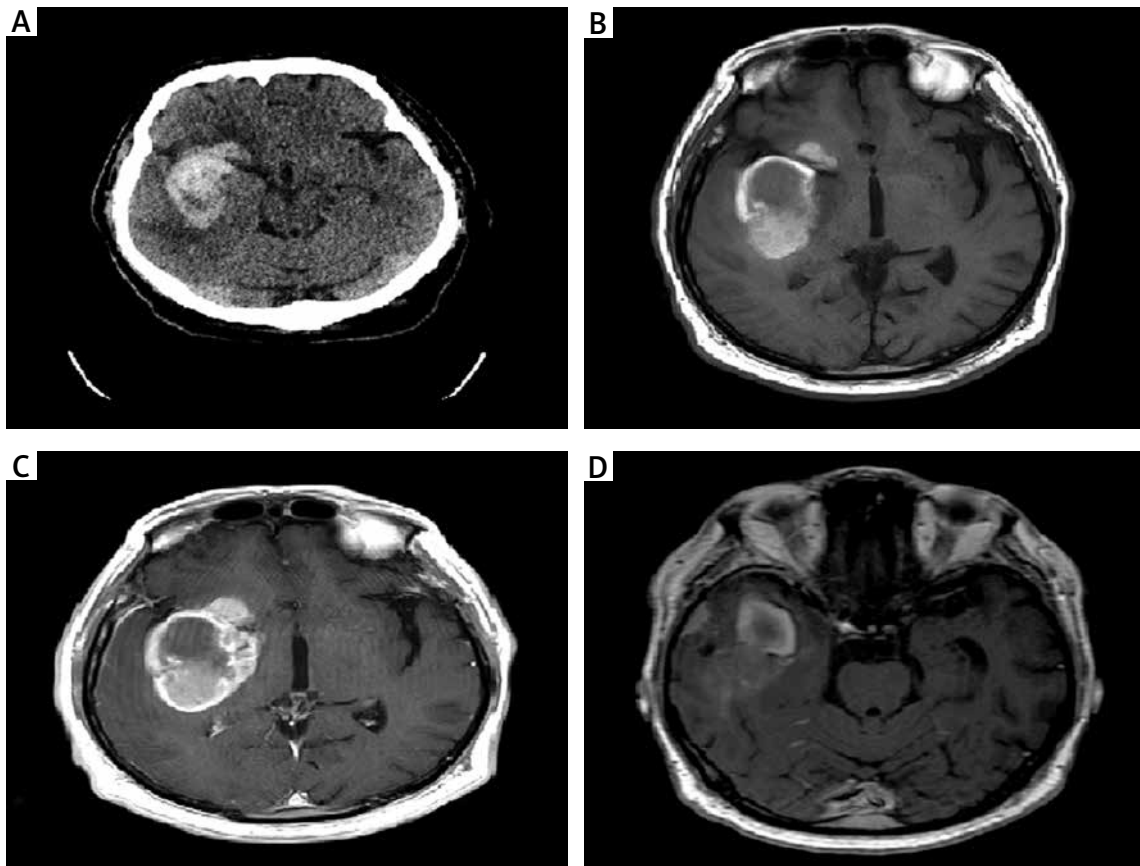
The computed tomography (CT) revealed the massive intracranial haemorrhage in the right hemisphere, localized mainly in the temporal and frontal lobes (A). The magnetic resonance imaging (MRI) without contrast showed a heterogeneous lesion in the right hemisphere (B). The MRI with intravenous contrast showed signs of peripheral contrast enhancement with intratumoral haemorrhage (C). Additionally, there was a homogeneous and well-circumscribed mass between the right temporal lobe and a skull with a broad dural base and strong enhancement indicating a small meningioma located in the right temporal region (D).
